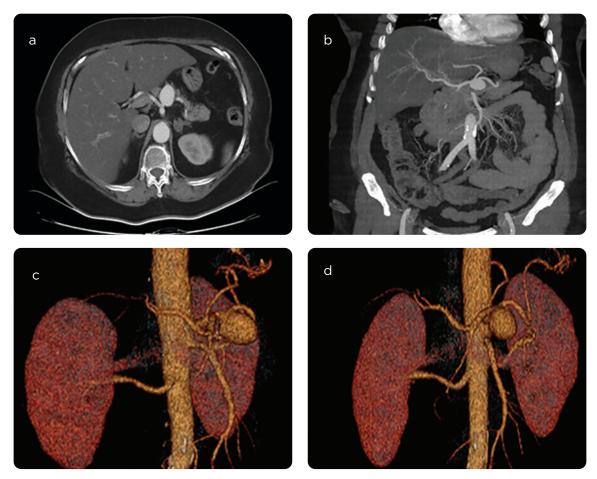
CT angiogram of abdomen. a) Axial section: saccular dilation of splenic artery proximal to 1 cm from its source. b). Coronal section: sacular dilation of 25×30 mm, at 10 mm from the origin of the splenic artery, 25×30 mm and with a neck of 1 mm in the proximal third of the splenic artery. c and d) Three-dimensional reconstruction.
